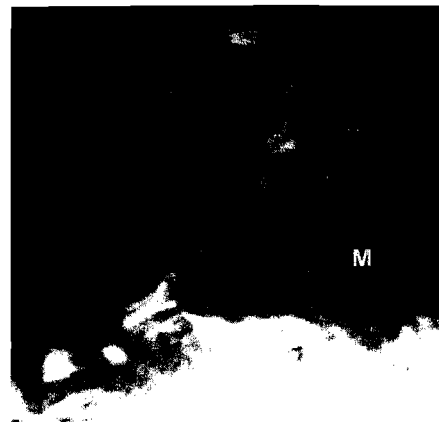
Axial T1-weighted MR scan in a patient with preganglionic Horner's syndrome, in the absence of brain or brain stem symptoms, reveals a large left apical lung mass (M) compatible with a Pancoast tumor. The mass appears to be extending into the neural foramen (arrowheads) (600/20/20).
